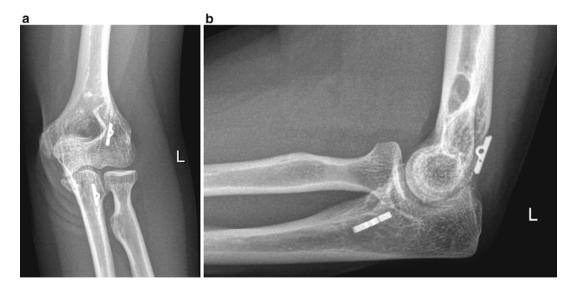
(a, b) Post-operative anteroposterior and lateral radiographic view of the elbow, showing correct placement of the buttons (Courtesy of MoRe Foundation)
